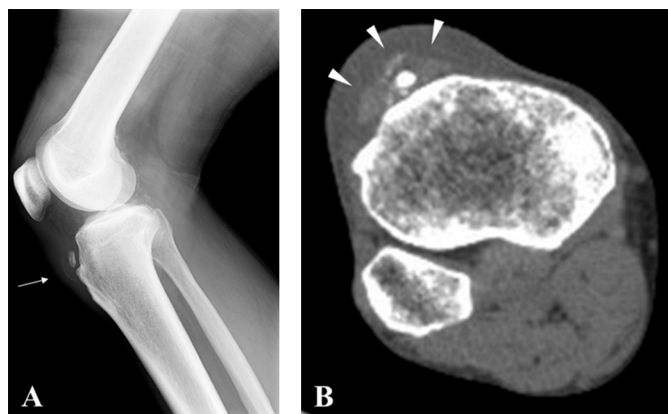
X-ray and CT scan showing that calcium deposits are apparent in the right knee (white arrow and white arrowhead).
